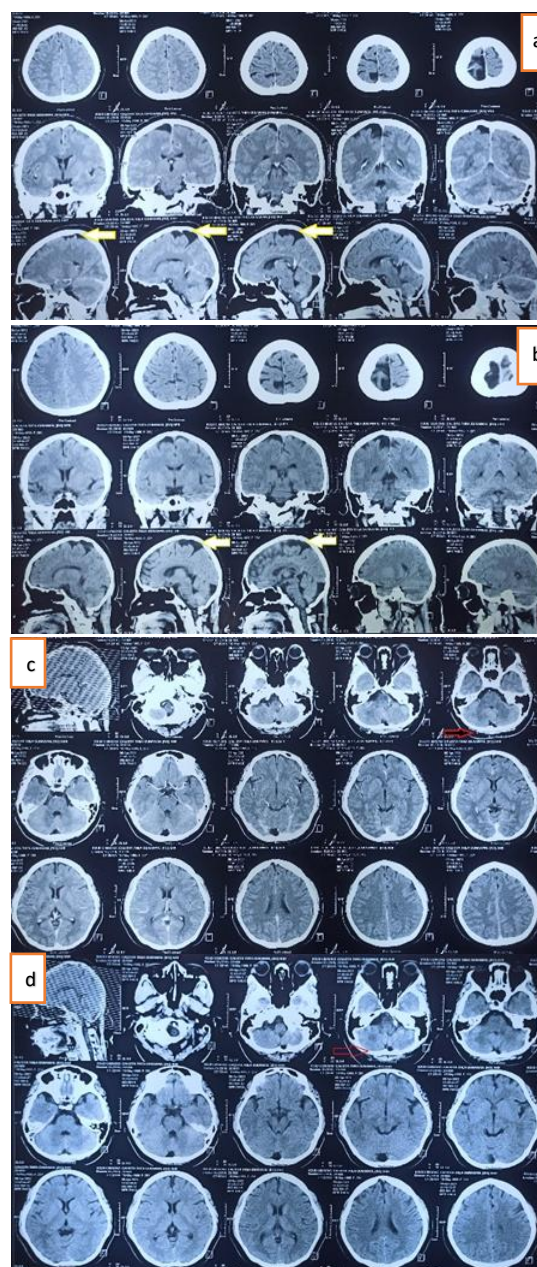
On computed tomography (CT) visualizing a hypodense lesion prominent in the posterior of cranial fossa and concavity of dextral parietal and concavity of dextral parietal in yellow arrows (a,b) and a hypodense
